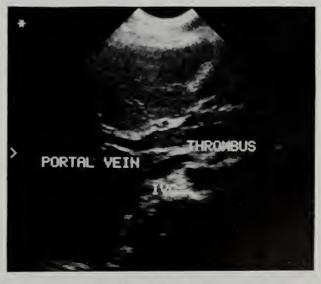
Abdominal ultrasound demonstrates thrombus in the portal vein
